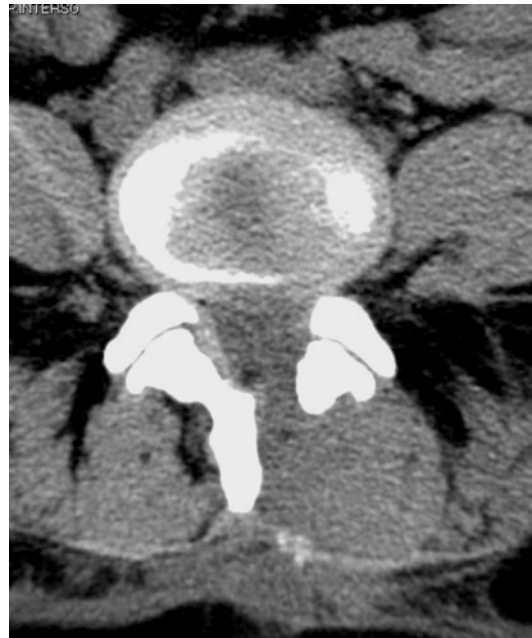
Axial CT image of L4-L5 disc soon after surgery. Imbibition, enlargement, and blurring of both the epidural space and disc with suggestion of residual disc protrusion
